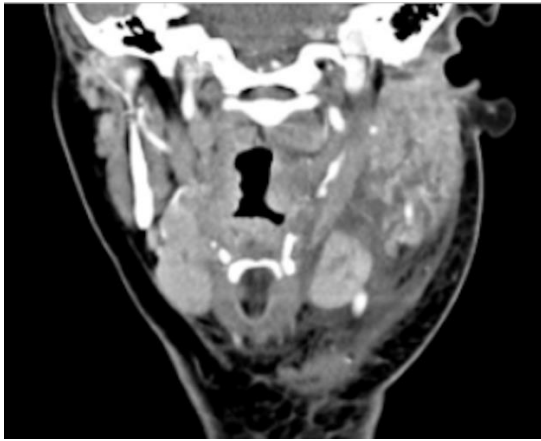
Axial image from a contrast enhanced CT of the neck demonstrates diffuse asymmetric swelling of the left parotid gland with surrounding fat stranding without associated obstructing stone, mass, or abscess.
